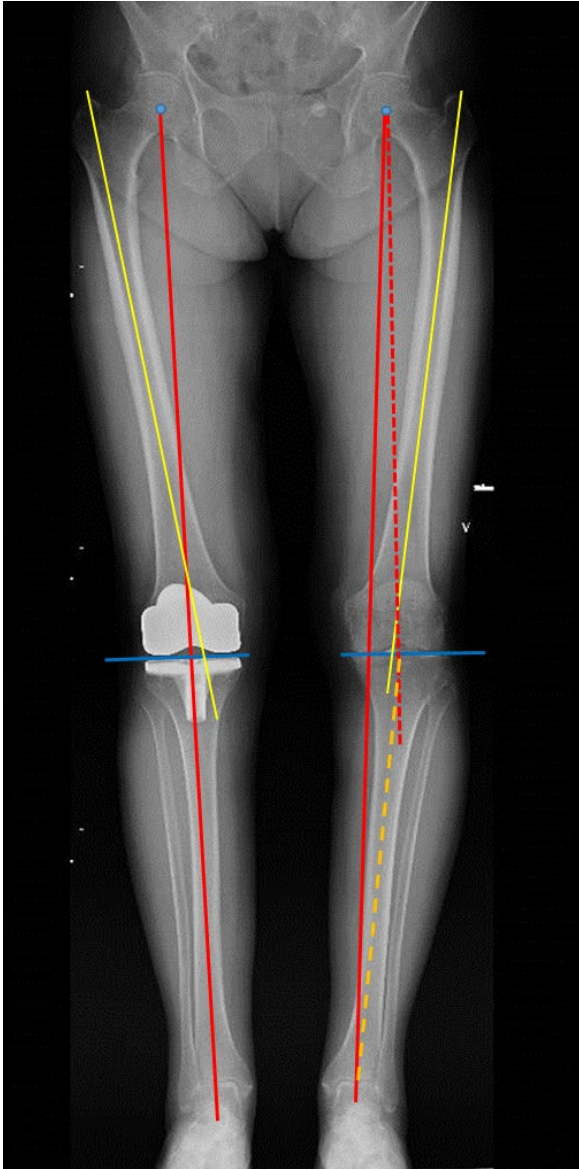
Standing HKA radiograph of both legs of a 69 year old woman operated with TKA in her right knee. The left knee suffers from arthrosis and has a small varus deformity. The previous varus deformity of the right knee has been corrected and the tibial and femoral components are placed perpendicular to the mechanical axes.
